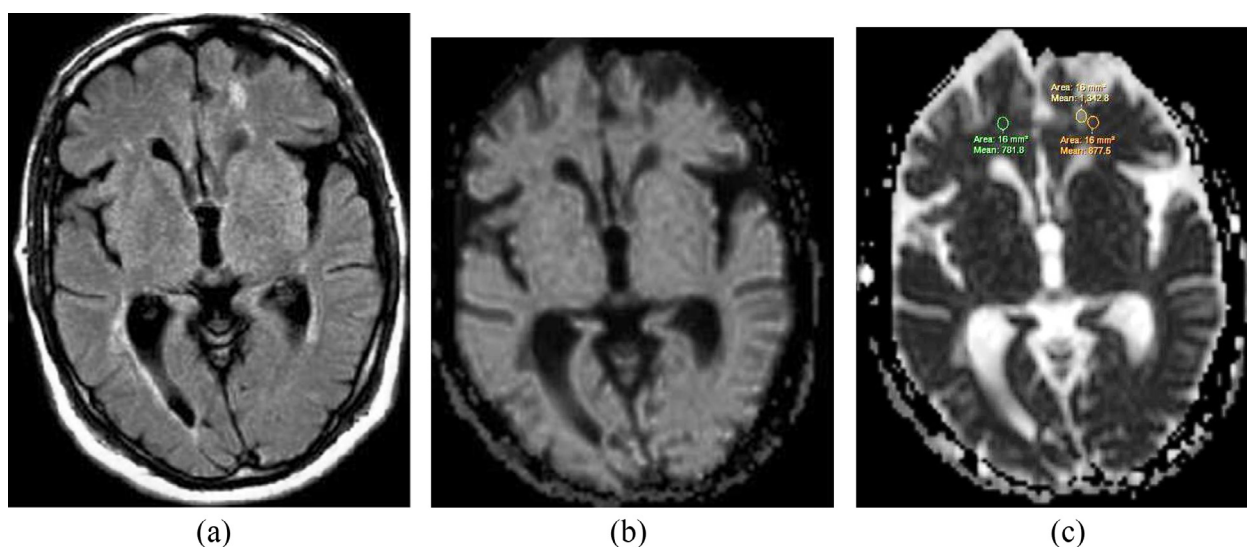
28 years-old Female patient with RRMS (4 years duration) and normal cognition (MOCA score 27). (a) Axial FLAIR showed multiple plaques, (b) DWI image showed signal intensity of facilitated diffusion, (c) ADC map showed the following readings: Plaque 1.3428×10^{-3} , Periplaque 0.8775×10^{-3} , and NAWM 0.7928×10^{-3} , $0.7818 \times 10^{-3} \text{ mm}^2/\text{s}$.
